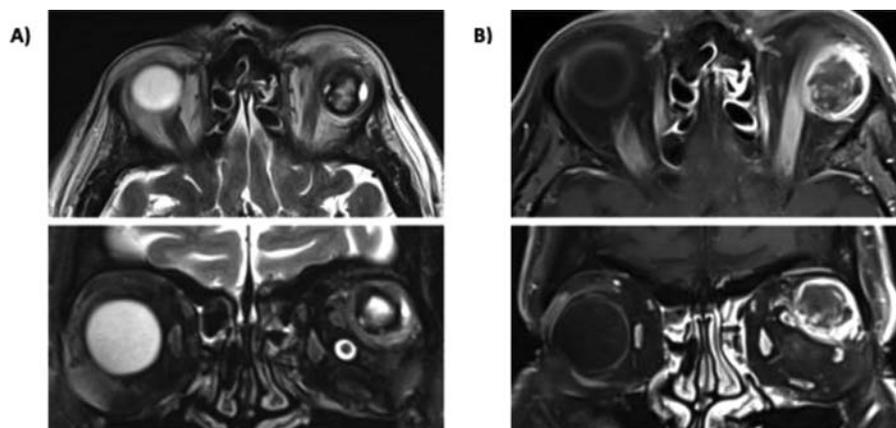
Radiologic findings of the LGPA with coagulative necrosis. (A) Magnetic resonance imaging axial (top) and coronal (bottom) T₂ images show the orbital mass in the left superolateral extraconal space. The lesion is heterogeneous with mixed regions of peripheral hypointensity and central hyperintensity. (B) Magnetic resonance imaging axial (top) and coronal (bottom) T₁, fat-suppressed, post-contrast images show prominent peripheral contrast enhancement with heterogeneous internal enhancement
